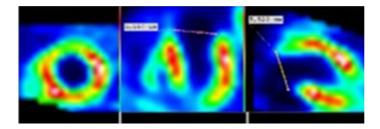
The tomoscintigraphy image myocardium before surgery.
